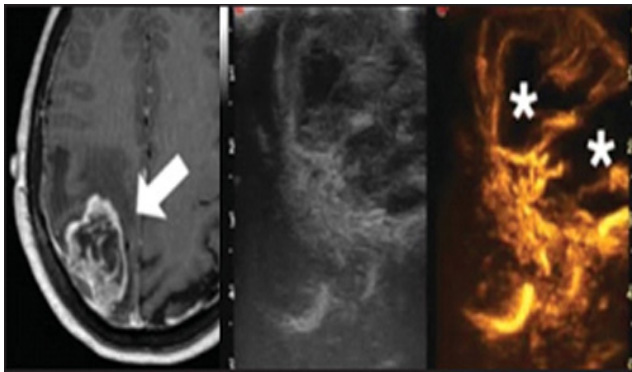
Contrast-enhanced magnetic resonance imaging and intra-operative ultrasound/contrast-enhanced US: High grade lesion can be compared, between the technologies. iUS can be used for the localization for most of the lesion, but with better results with cystic/heterogeneous tumors. Contrast-enhanced US has good visualization in vascularized tumors and give intra-operative vascular aspects. Images from Prada *et al.*^[51]
